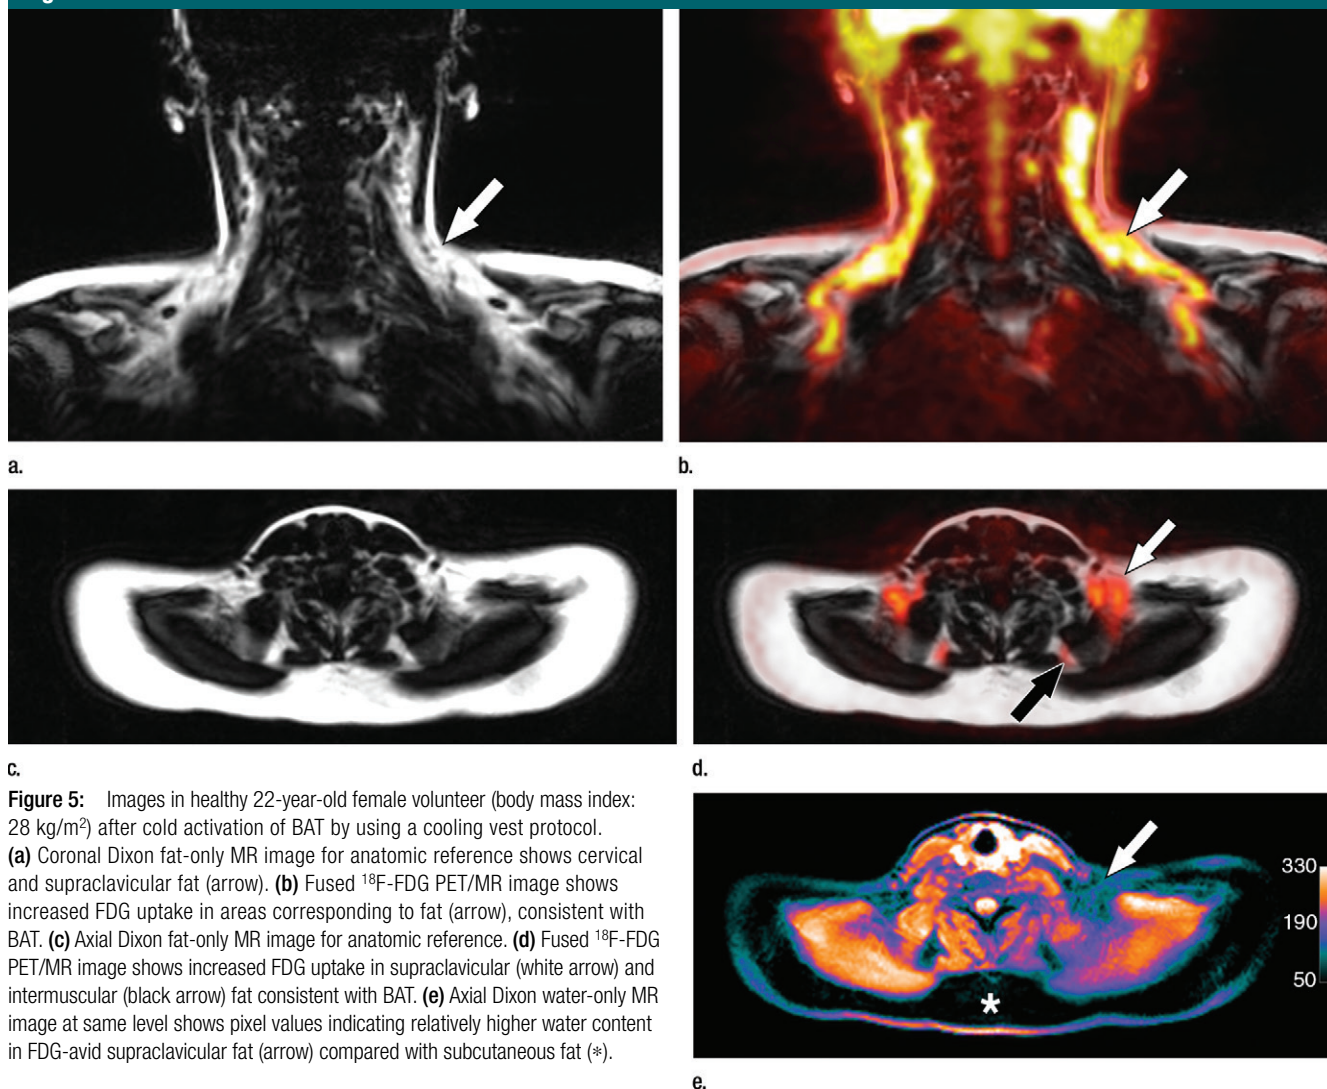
Images in healthy 22-year-old female volunteer (body mass index: 28 kg/m²) after cold activation of BAT by using a cooling vest protocol. (a) Coronal Dixon fat-only MR image for anatomic reference shows cervical and supraclavicular fat (arrow). (b) Fused ¹⁸F-FDG PET/MR image shows increased FDG uptake in areas corresponding to fat (arrow), consistent with BAT. (c) Axial Dixon fat-only MR image for anatomic reference. (d) Fused ¹⁸F-FDG PET/MR image shows increased FDG uptake in supraclavicular (white arrow) and intermuscular (black arrow) fat consistent with BAT. (e) Axial Dixon water-only MR image at same level shows pixel values indicating relatively higher water content in FDG-avid supraclavicular fat (arrow) compared with subcutaneous fat (*).
